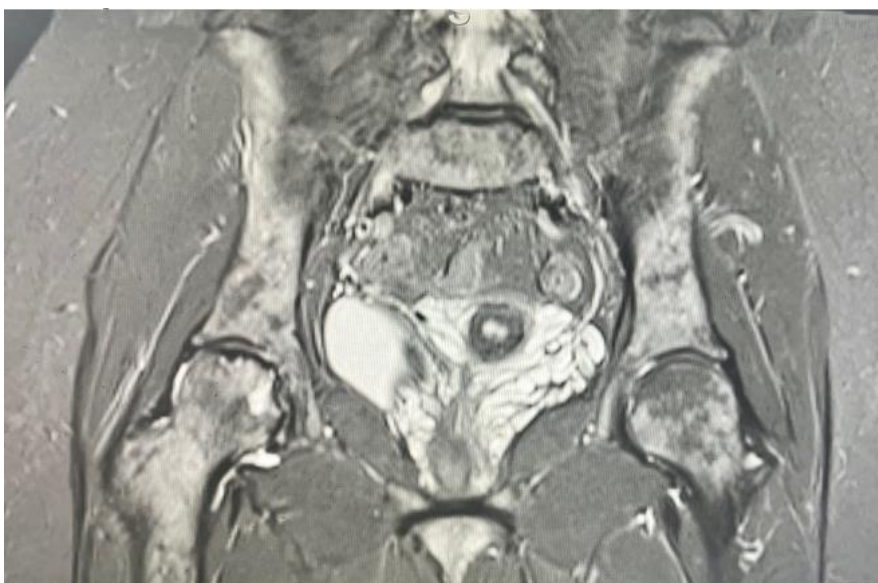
A coronal cut of MRI of the pelvis showing AVN of the right femoral head Ficat stage 3 with subchondral collapse.
